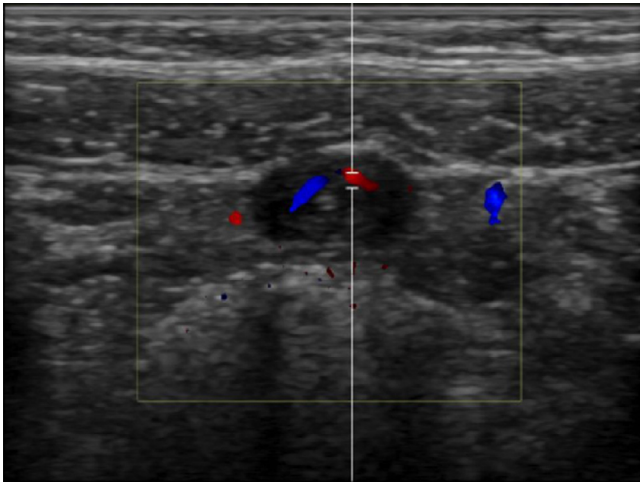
Transverse ultrasound along the midline just superior to the bladder. A hypoechoic mass with punctate hyperechoic center with internal symmetric doppler flow is identified. This mass is contiguous and demonstrates the same echogenicity as the bladder.
